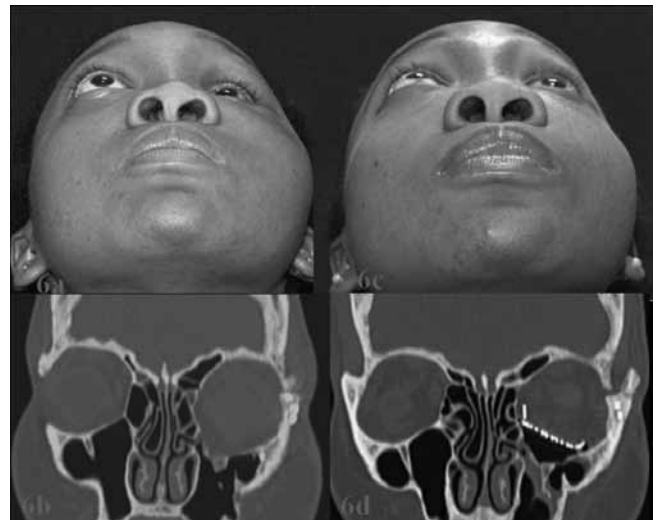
Preoperative axial view (a) of the patient and pre-operative coronal CT scans (b). Left enophthalmos is evident. Postoperative axial view (c) of the patient and postoperative coronal CT scans (d). A titanium mesh was positioned on the left orbital floor to the medial wall, and left enophthalmos was no longer apparent.
